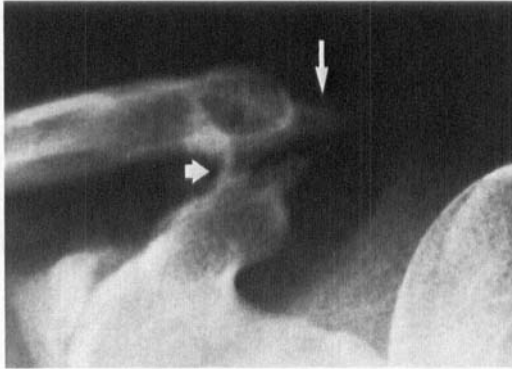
Radiograph of the left acromioclavicular joint of a 40-year-old woman operated on 3 years earlier with resection of the clavicle and transposition of the coracoacromial ligament. There is new bone formation into the resection gap from the clavicle (long arrow) and also between the clavicle and the coracoid process (fat arrow). The follow-up result was rated good.
